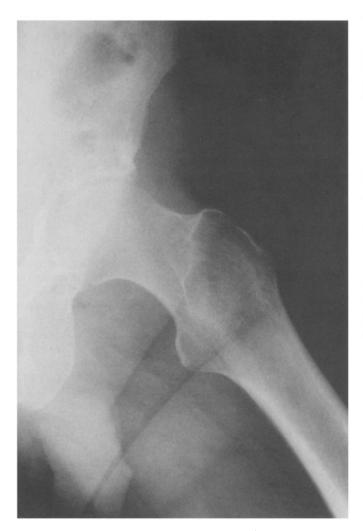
Initial X-ray film of the femoral head.
